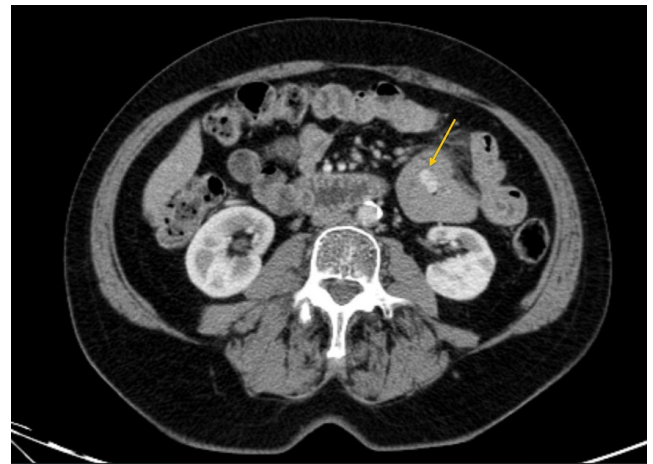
Axial CT scan shows a hypervascular lesion on jejunum.
